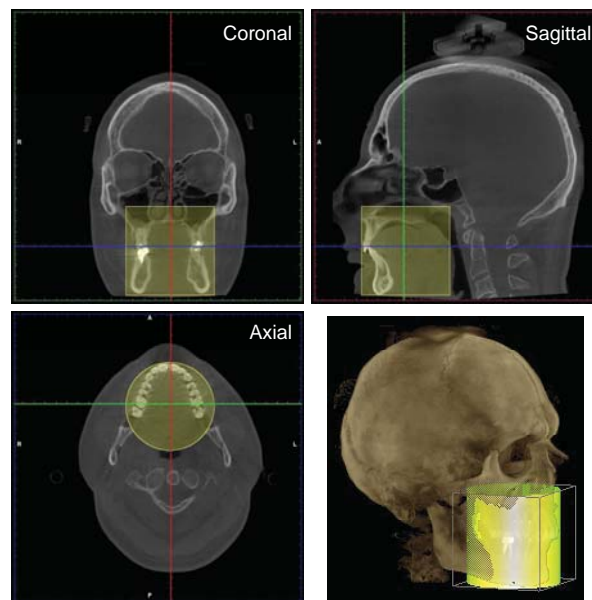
The field of view (FOV) was a cylinder of 80 mm in diameter and height. The lower right panel is a 3D rendering of a full-skull CBCT image, whereas the other panels represent cross-sections of the same image, taken in the axial, coronal and sagittal plane.
